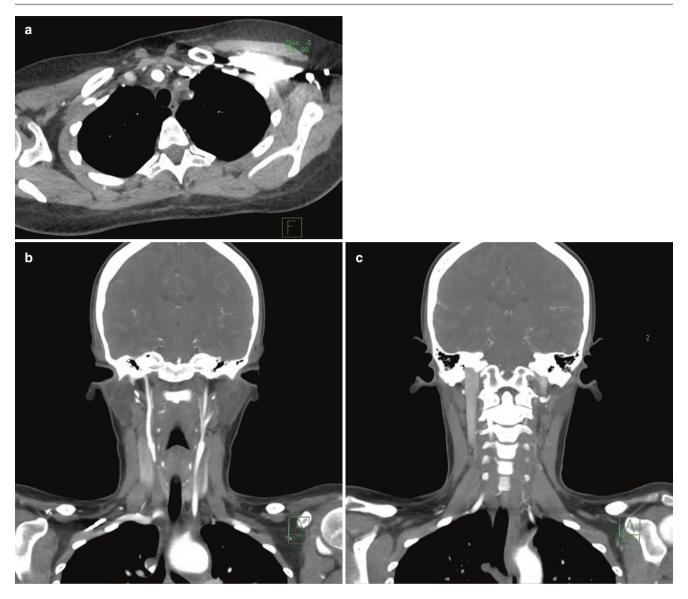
Takayasu arteritis. (a) Axial contrast-enhanced CT of vasculitis—circumferential soft tissue thickening of the supra-aortic vessels with luminal narrowing. (b) Coronal contrast-enhanced CT shows
